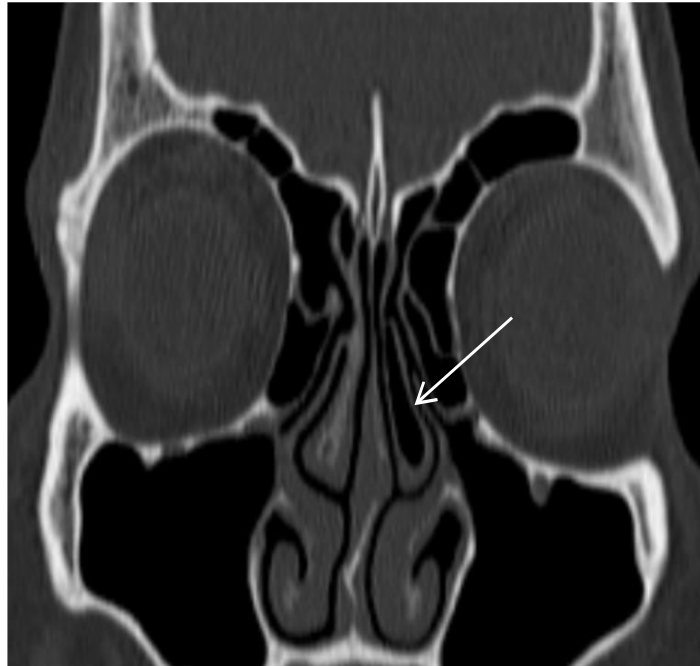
CT PNS Coronal view, (Bone window), Left concha lamella and concha bullosa
